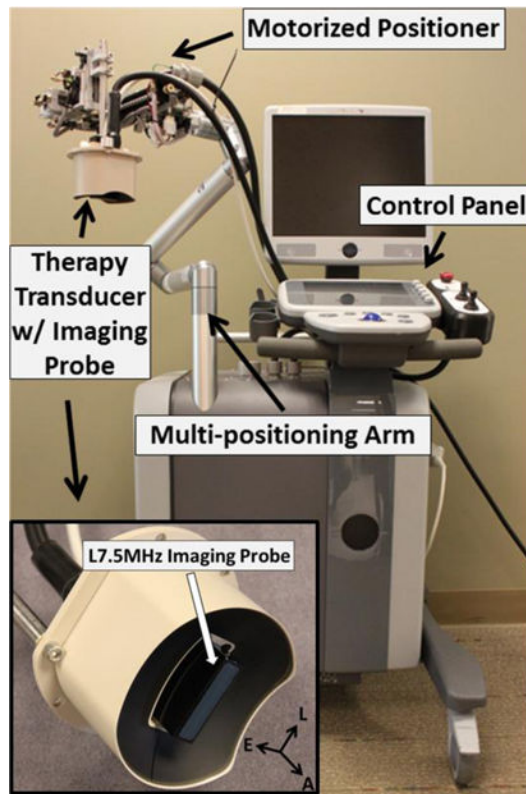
Integrated microthrombolysis system. It consists of an ultrasound imaging system, a microthrombolysis therapy system, and a motorized positioning system. The insert shows the therapy transducer with a linear imaging probe embedded at the center.
